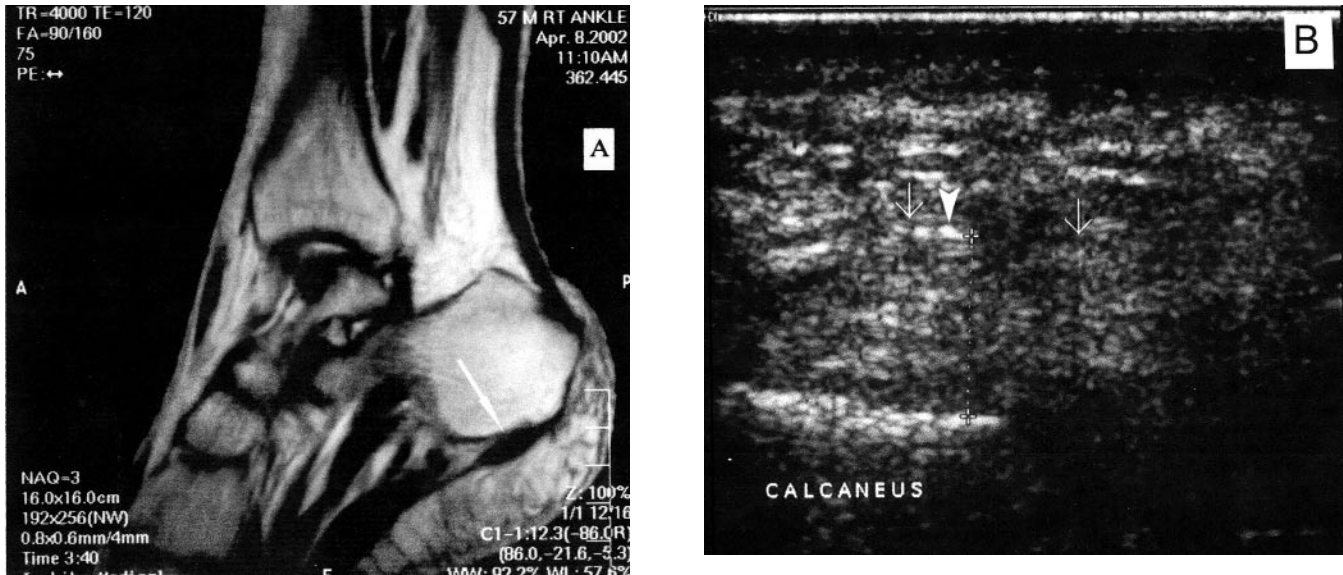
A. Sagittal T2 weighted MR image of the heel showing only focal thickening of the plantar fascia near its insertion. B. US image of the plantar fascia showing diffuse thickening (1.04 cm) through its whole length and presence of several calcification foci (arrowhead) (12 MHz).
